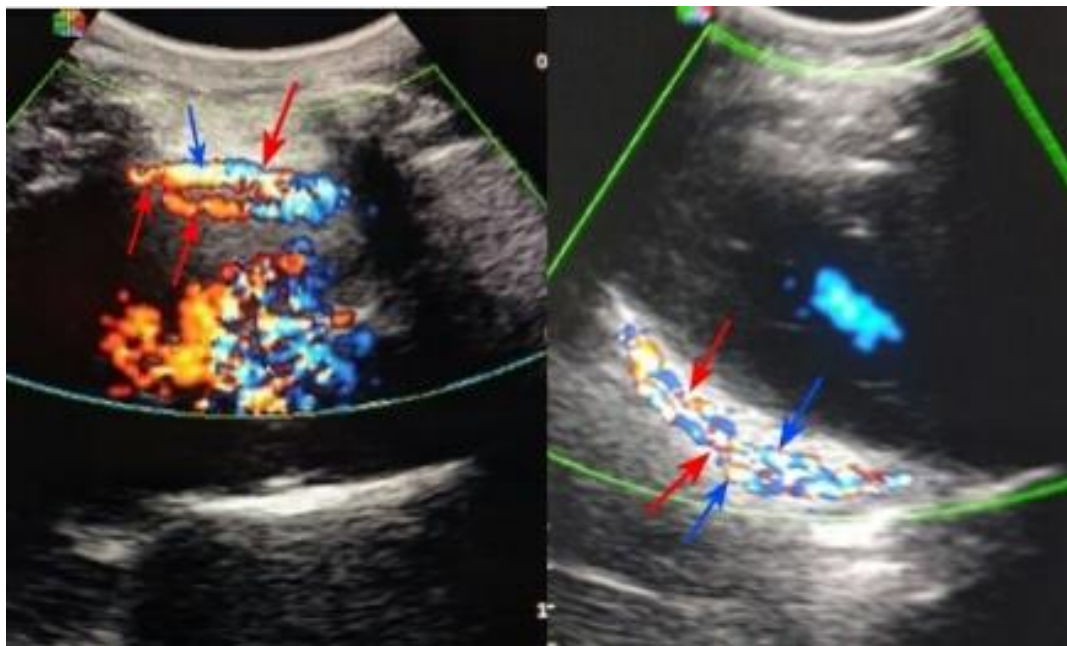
long parasternal view & modified one's (in direction opposite to figure 2), show the anterior & posterior descending CAs respectively, with the stenosis (red arrows), and dilatation (blue arrows).
